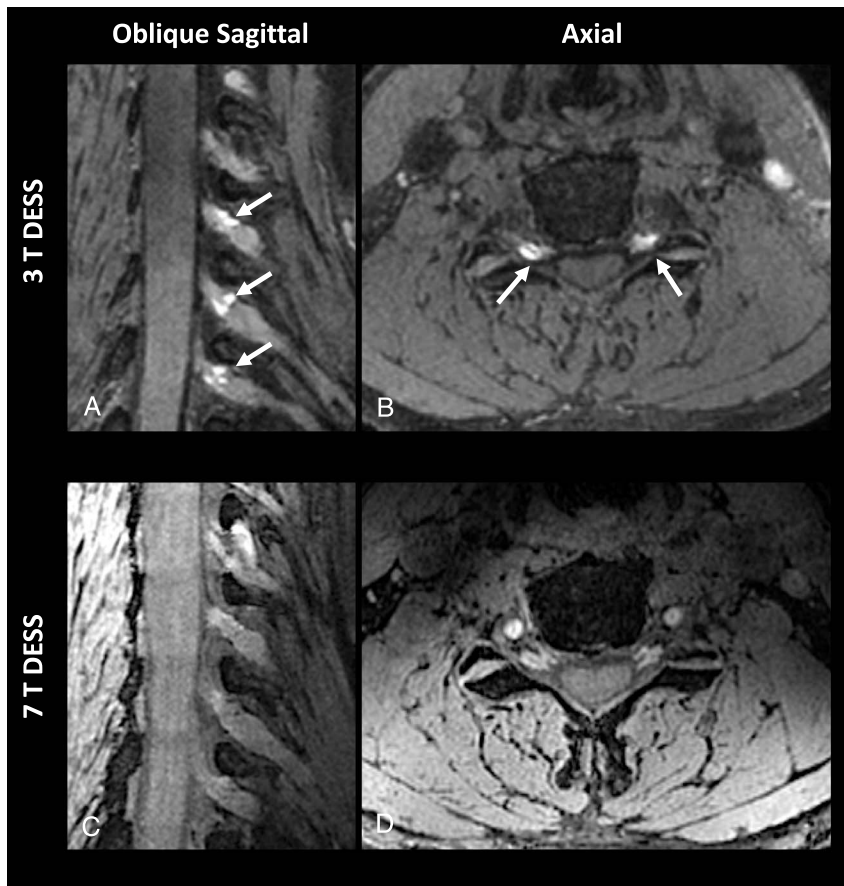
Oblique sagittal and axial reformations of a 3D DESS sequence of the cervical spine acquired at 3 T MRI (A and B) as well as on 7 T MRI (C and D). Note that the 3 T MRI is more susceptible to the low velocity of the CSF at the level of the neuroforaminal recesses resulting in a focal signal increase and reduced accessibility of the cervical nerve root (arrows) compared with 7 T MRI. CSF, cerebrospinal fluid.
